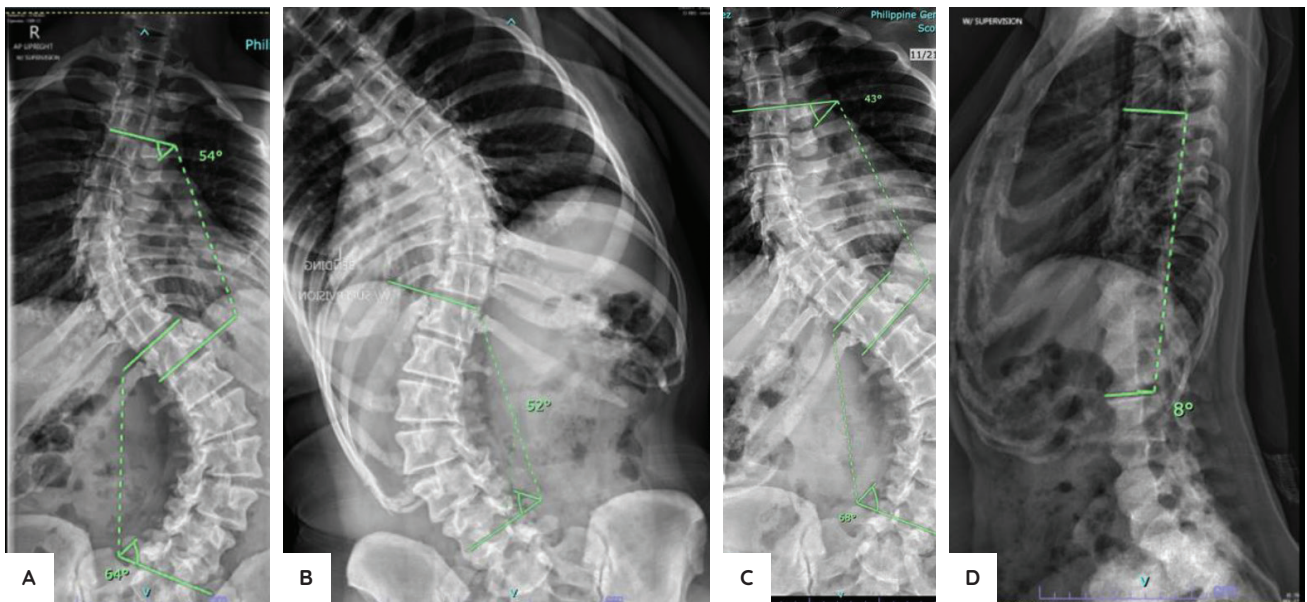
Patient B pre-operative x-rays (with bending views). Standing thoracic and lumbar AP x-rays showing curve measurements for thoracic and lumbar curves (A). Bending views showing amount of correction achieved for the lumbar curve (B). Bending views showing amount of correction achieved for the thoracic curve (C). Lateral x-ray showing below-normal sagittal alignment (Reference: 10–40 degrees) indicating a hypokyphotic spine (D).
